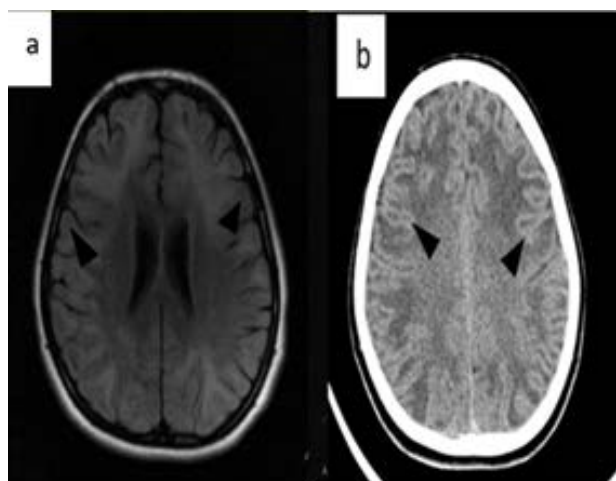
13 years old girl's brain axial FLAIR MR and axial CT imagings mention cerebral subcortical white matter lesions in bilateral frontal and parietal lobes: a) diffuse hyperintense areas (black arrowhead); b) diffuse hyperdense areas (black arrowhead)
